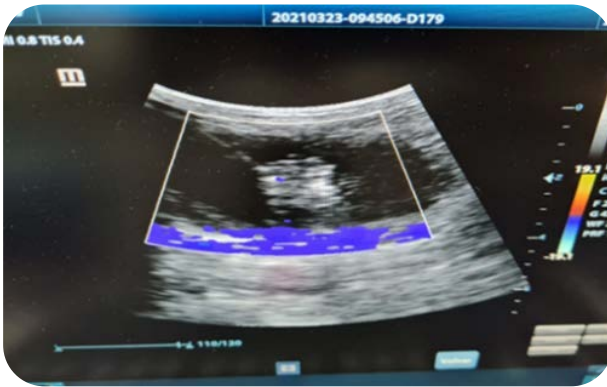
Ultrasound-guided puncture.
